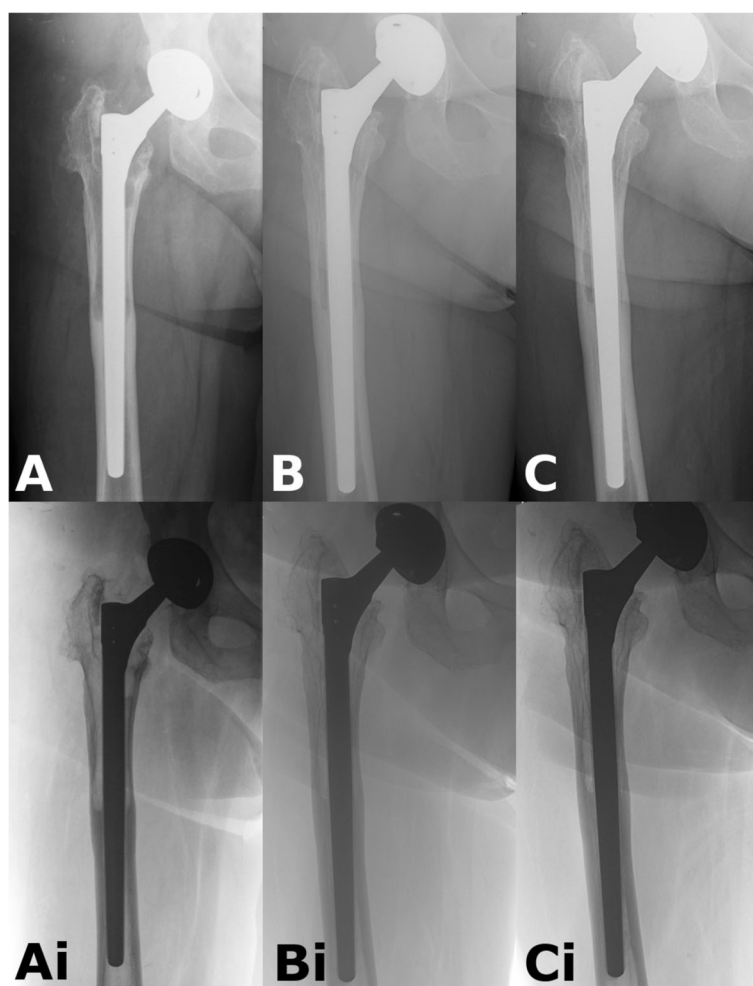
Example for AL case. a: Postoperative radiograph after revision. Obvious proximal femoral lysis. b: After 12 months there is mild subsidence, and continuous bony remodeling. c: Almost complete reconstitution of bone stock at 2 years. Ai-Bi-Ci: Shows the same pictures in inverted view (Patient 17)
